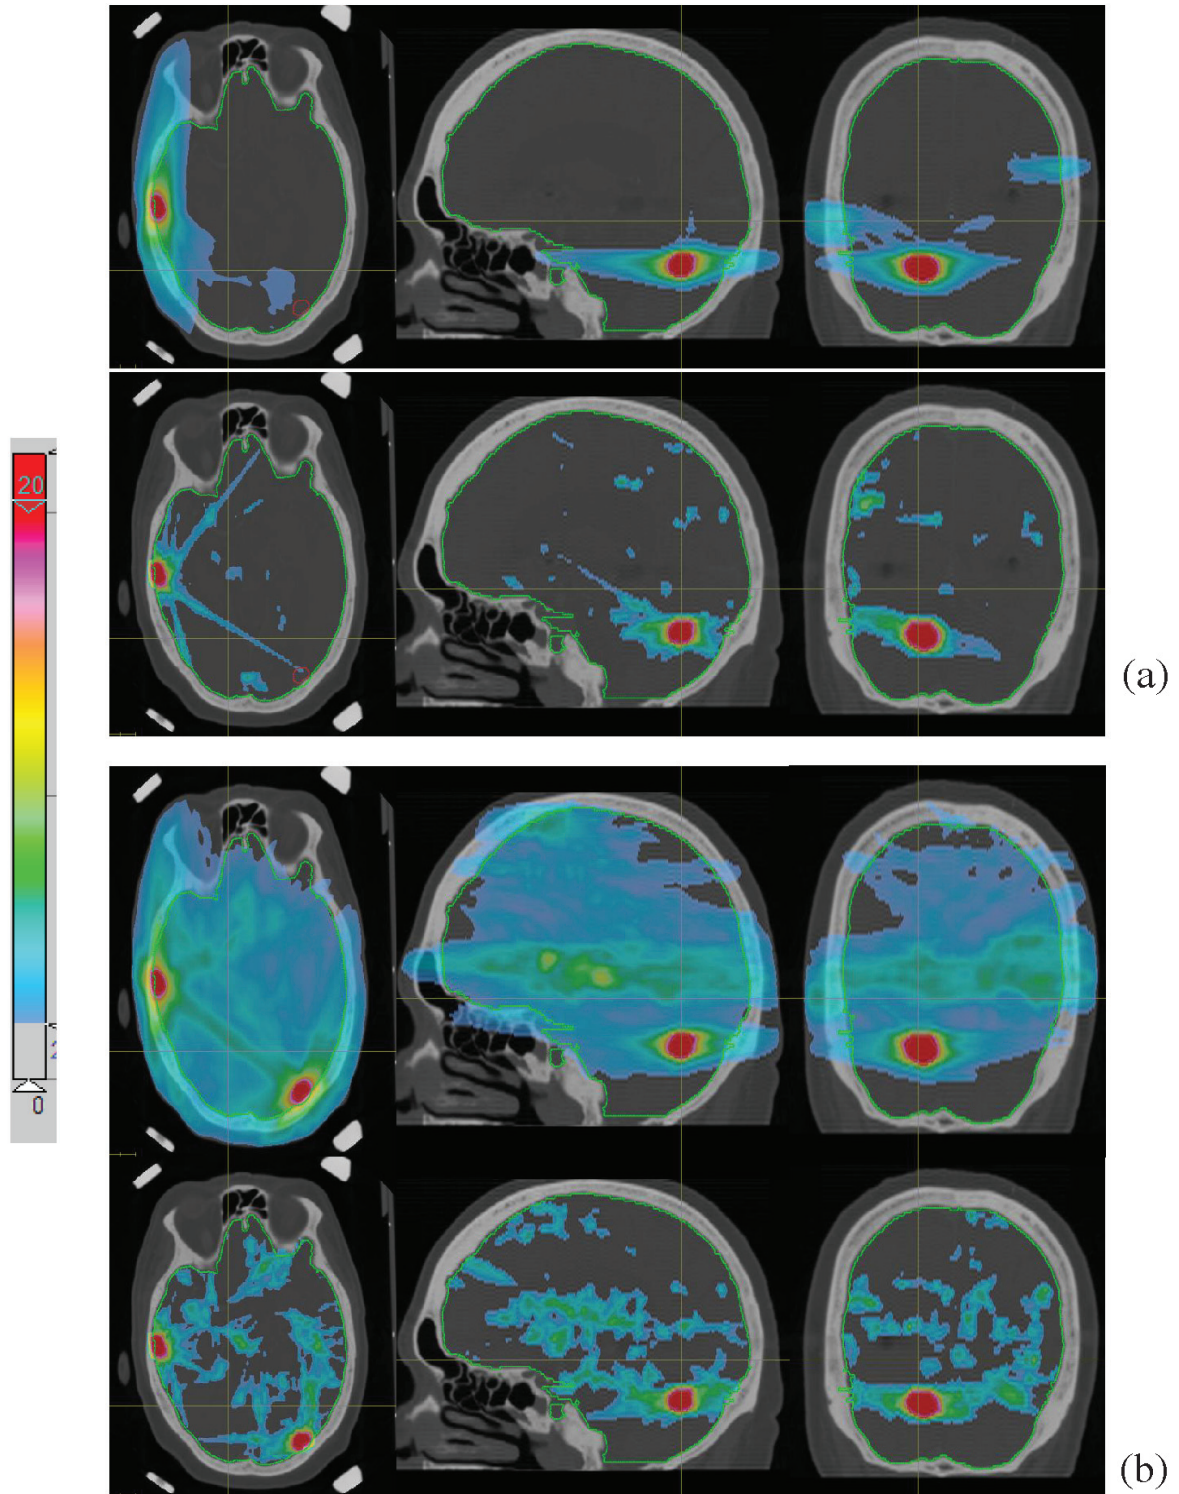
Comparison of low-level normal brain spillage isodose distributions for the case of N=3 (panel a) and N=12 (panel b) for the 6 MV x-ray treatment plans. In both panel (a) and (b), the top figures are the noncoplanar 4-arc VMAT treatment plans and bottom figures are the BROOMBA treatment plans via 20 non-coplanar beams. Note the area difference in the low dose levels between the two techniques.
